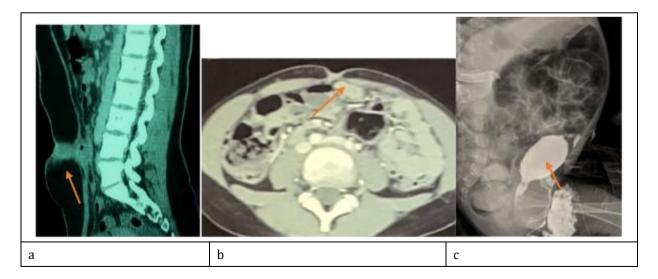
(a) (b) Abdomino-pelvic CT scan indicating a fistulized urachal abscess, (c) Contrast-enhanced fistulography through a urinary catheter showing the fistulous tract between the bladder and the urachus
